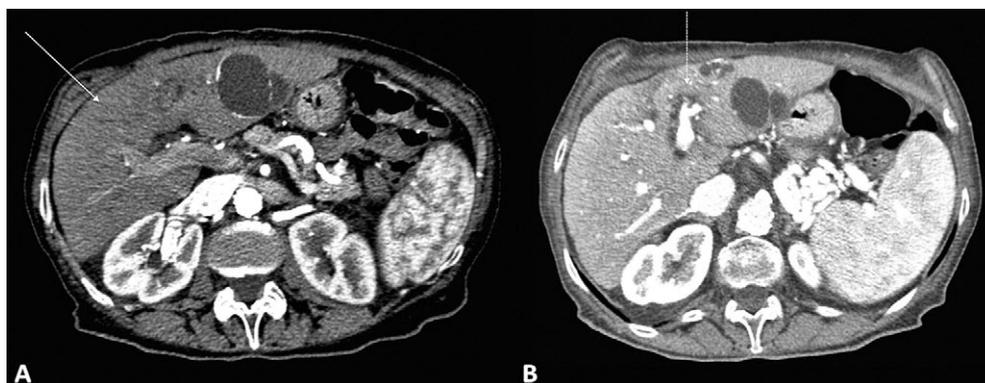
CT scans of the abdomen performed at the 10th month of therapy. (A) Arterial phase shows that HCC lesion has been replaced by an isoattenuating to liver parenchyma, non enhancing area (arrow). (B) Hepatic venous phase and delayed phase CT scan shows recanalization of the left portal vein branch (dotted line).
